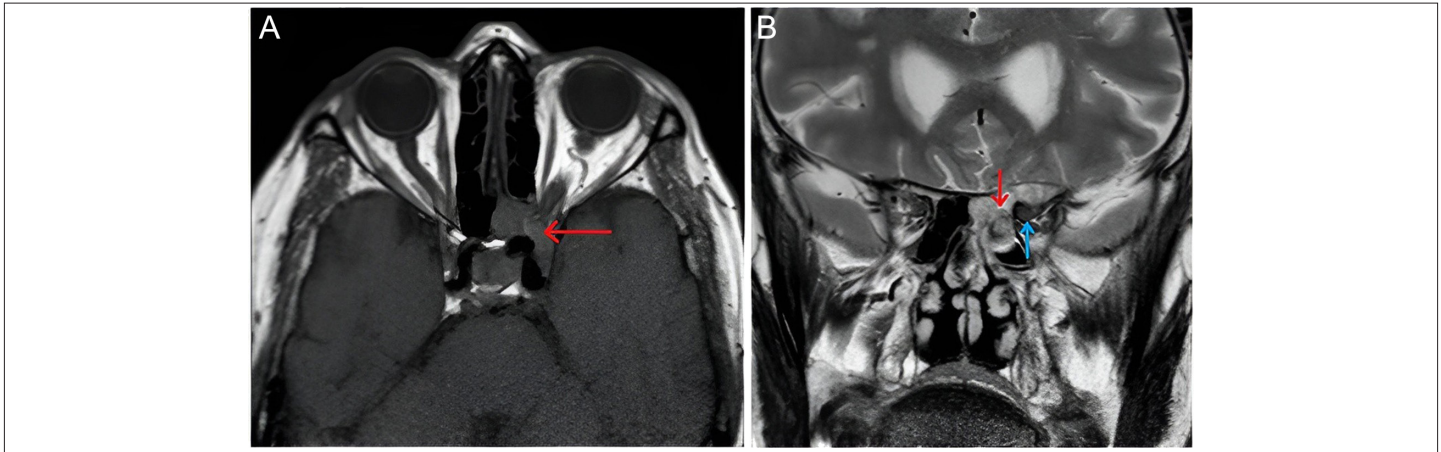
Orbital magnetic resonance images: (A) axial section T1 and (B) coronal section T2 (red arrow: mass located in left orbital apex and left sphenoid sinus and blue arrow: optic nerve).
